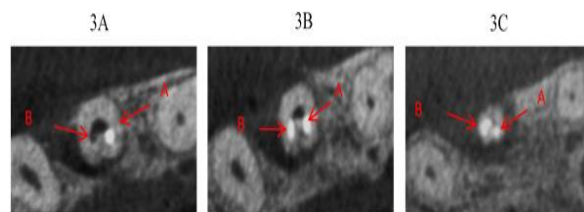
(A) Cone-beam computed tomography (CBCT; axial view of the coronal third); the main root canal is pushed laterally by the invagination. (B) CBCT (axial view of the middle third); the main root canal and the invagination. (C) CBCT (axial view of the apical third); two apical openings, one is the pseudoforamen of the invagination and the other is the apical foramen of the main root canal
